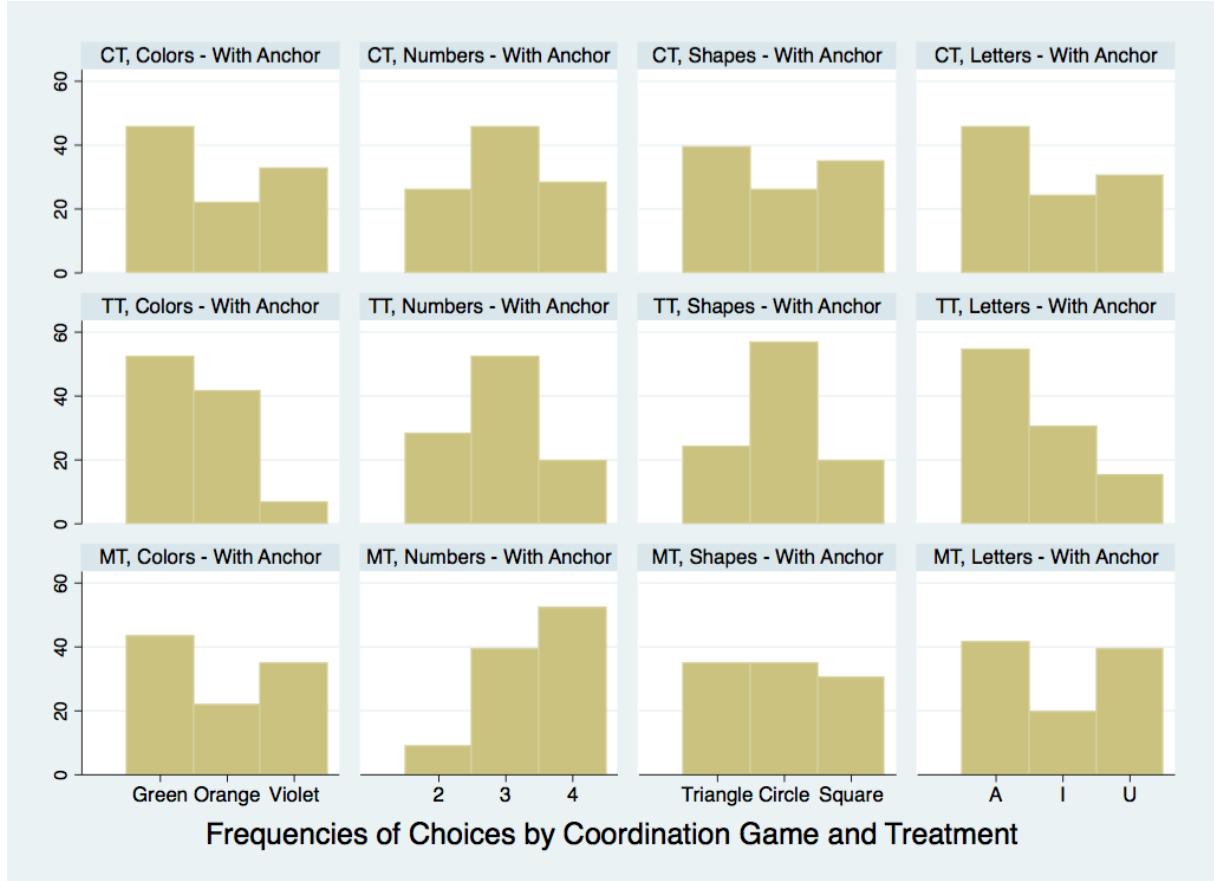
Distribution of choice by coordination game played and treatment (CT = Control Treatment, TT = Time pressure Treatment, MT = Motivation Treatment) when the anchor on the third option was provided. In each of the twelve subgraphs, the left bar represents the first option, the central bar the second option and the right bar the third option. Options are, respectively, Colors: green-orange-violet, Numbers: 2-3-4, Shapes: triangle-circle-square, Letters: A-I-U.
